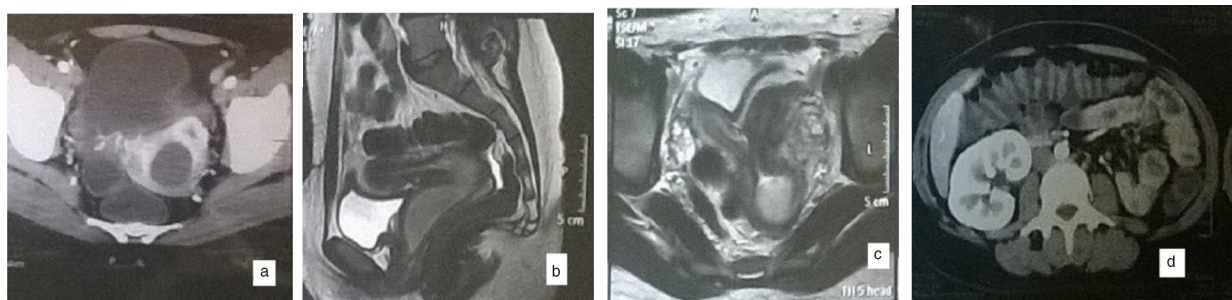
Computerized tomography (CT) revealed vaginal cystic mass with bicornuate uterus (a), magnetic resonance imaging with uterine cavity communicating with the cystic mass in vagina with bicornuate uterus (b,c), CT revealing hydronephrotic right kidney with absent left one (d).
